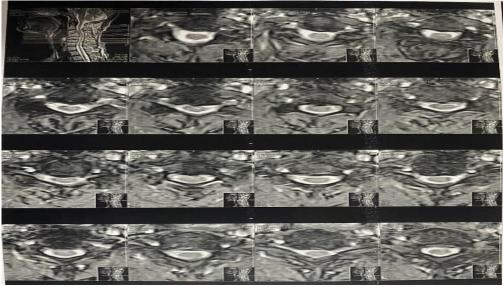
Axial cervical radiographs.
